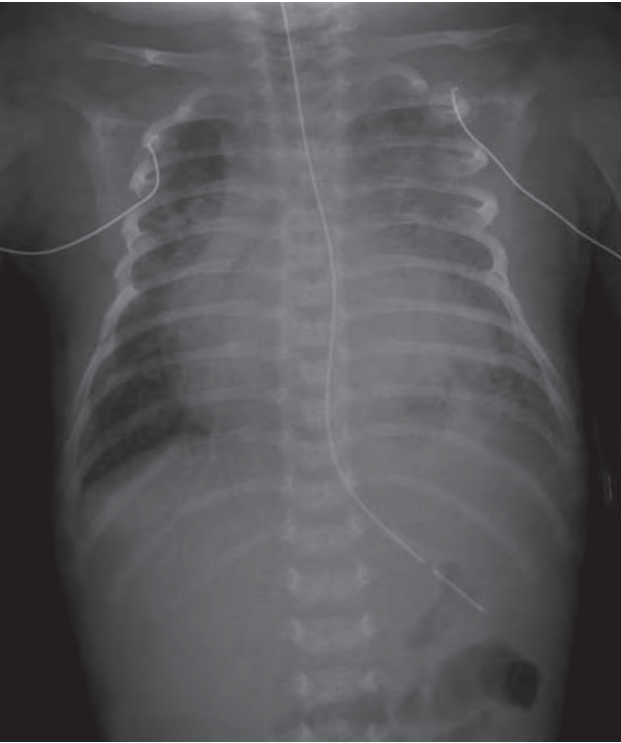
Chest X-ray obtained in a 15-day-old infant presenting with new onset respiratory distress. Note the marked cardiomegaly with pulmonary venous congestion and blunted left costophrenic angle.
